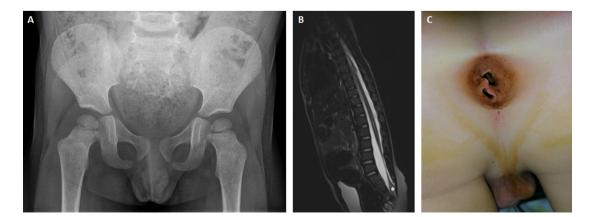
A. Initial radiograph of the pelvis: sacral agenesis. B. Tethered spinal cord syndrome associated with lipoma of the filum terminale (white asterisk) (MRI before surgery, sagittal view, T2 sequence). C. Anal adhesion.
